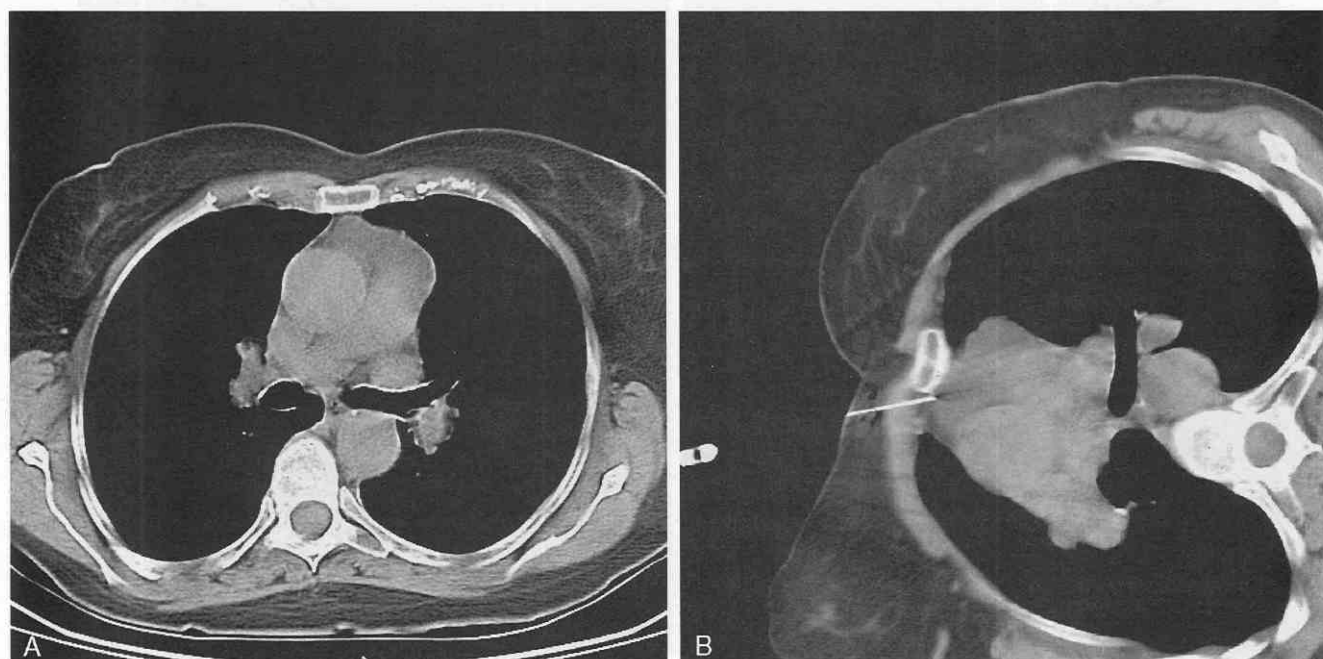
A, CT scan shows an ill-defined mass in the anterior mediastinum, believed to be subtle mass in thymus. With the patient in the prone position, access to the mass cannot be obtained without crossing the lung. B, When the patient is positioned on the side the mediastinal structures shift, permitting access for needle placement into the mediastinum.
